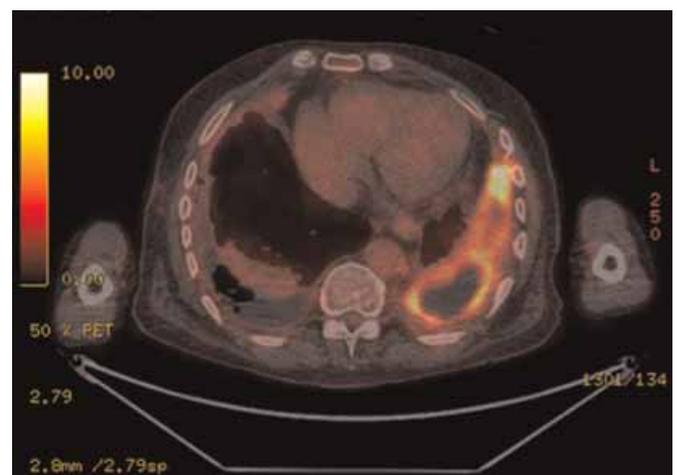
2-Fluoro-2-deoxy-D-glucose (FDG)-avid pleural thickening in non-malignant pleural disease following video-assisted thoracoscopic surgery biopsy and talc pleurodesis.
